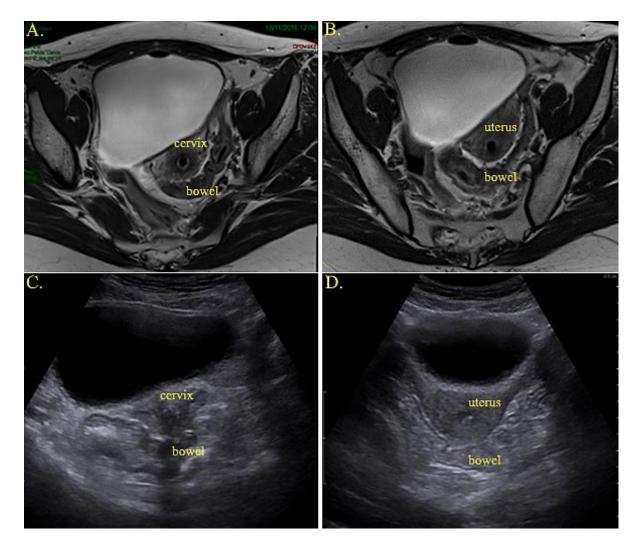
ICRU 38 bladder and rectal points on MRI and ultrasound images
